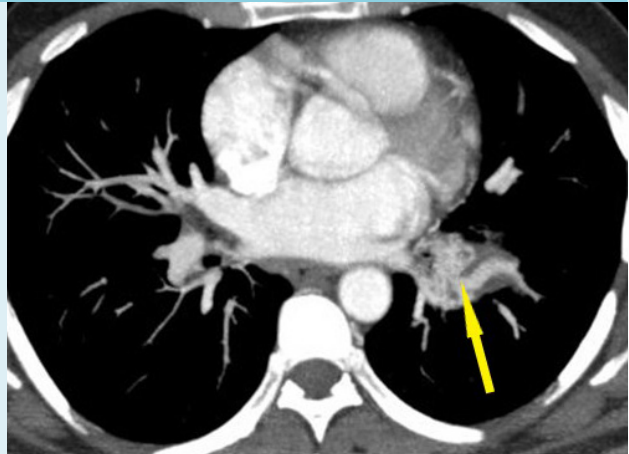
CT Scan chest axial view
